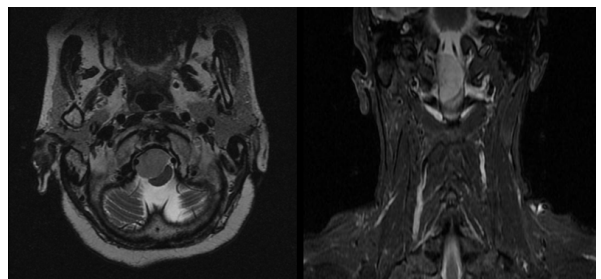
On axial non-contrast T2WI and coronal STIR MR images, the lesion appears iso-hyperintense on T2WI and hyperintense on STIR.
